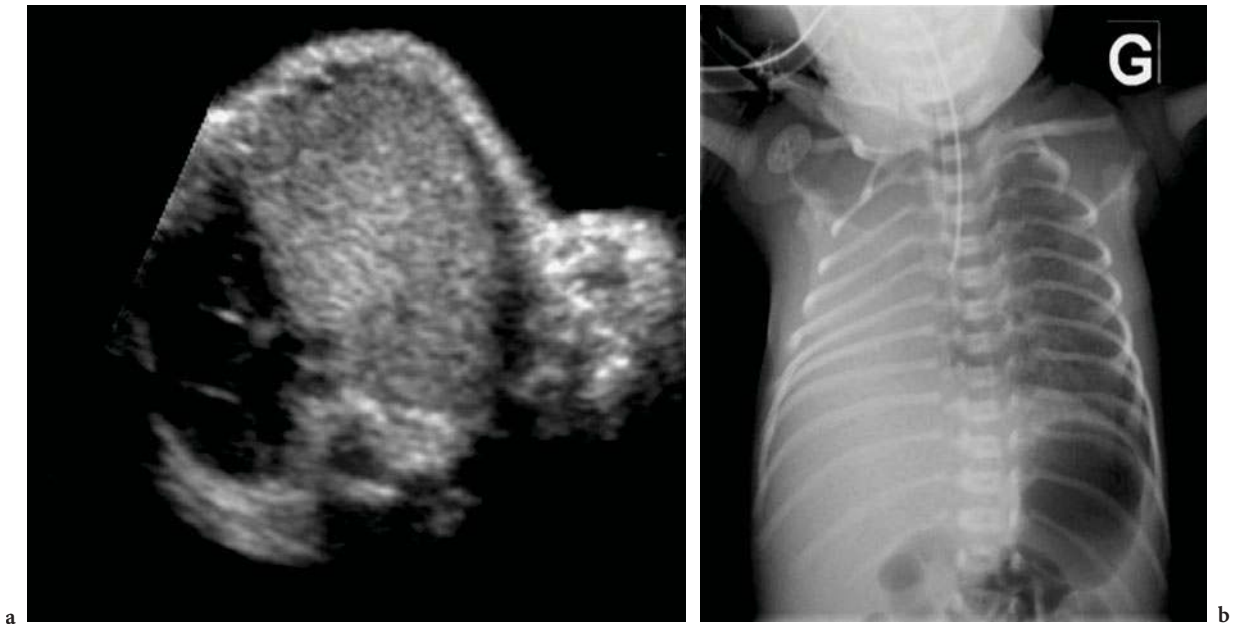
Right lung agenesis associated with esophageal atresia. a Transverse scan of the fetal thorax showing the extreme shift of the heart by the left lung. b Chest X-ray at birth
